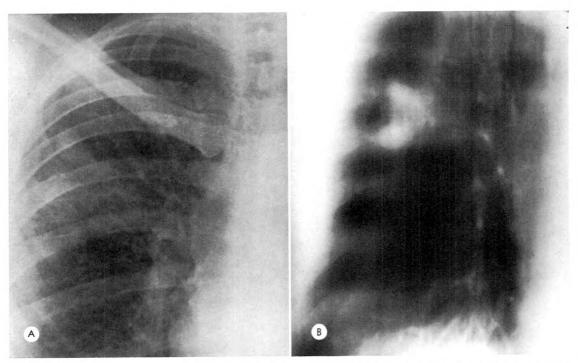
(A) Posteroanterior roentgenogram and laminagram of the right upper lobe demonstrating mucoid impactions involving the bronchi to the anterior and posterior segments of the right upper lobe. Impacted mucus in these bronchi forms a characteristic "V" configuration as the bronchi converge upon the right upper lobe bronchus.
